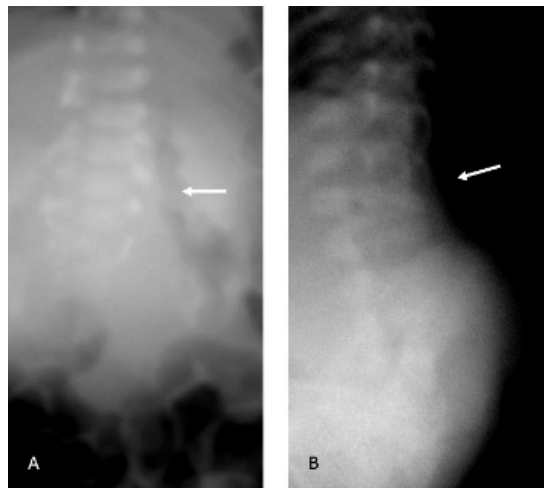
X-ray images of Patient 1 lumbosacral spine. (Anterior-posterior X-ray; Lateral X-ray; arrow indicating the vertebral deformation zone).
